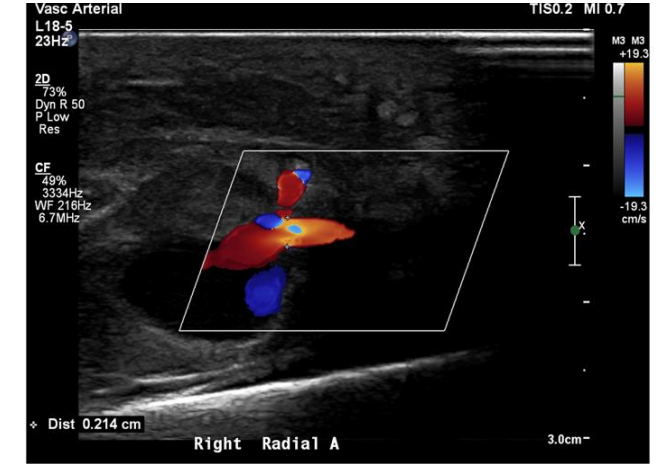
The pseudoaneurysm was arising from the radial artery with a neck diameter of 0.2cm as visualised on colour doppler
